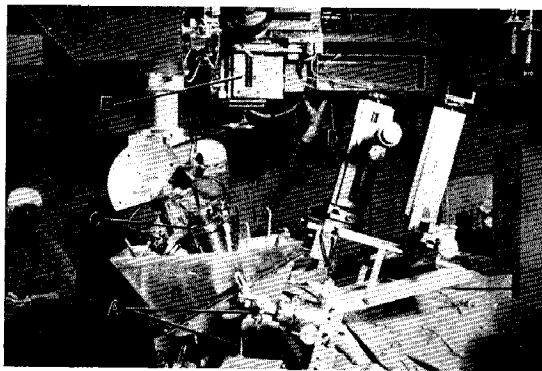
The ultrasonic equipment is shown in the operating room. The patient's head is secured in the stereotaxic head holder (A). The transducers (C) are immersed in the degassed saline transmitting bath (B). The carriage control panel (D) and overhead positioning carriage are shown (E).
